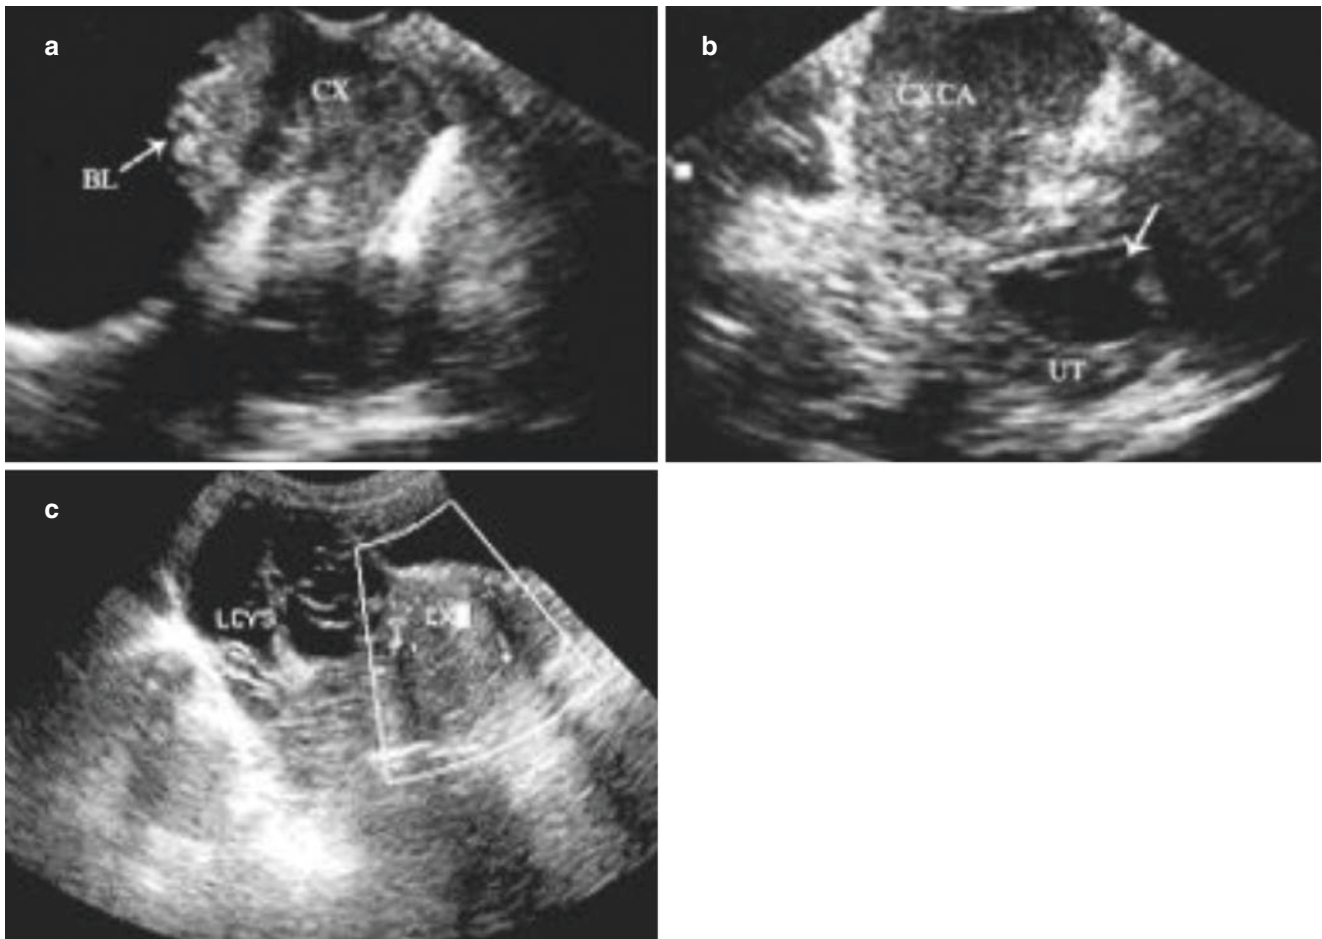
Cervical cancer infiltration. (a) Sonogram shows the enlarged cervix with abnormal shape, and the mass infiltrated into the bladder wall (arrow). (b) Sonogram shows the enlarged cervix without
